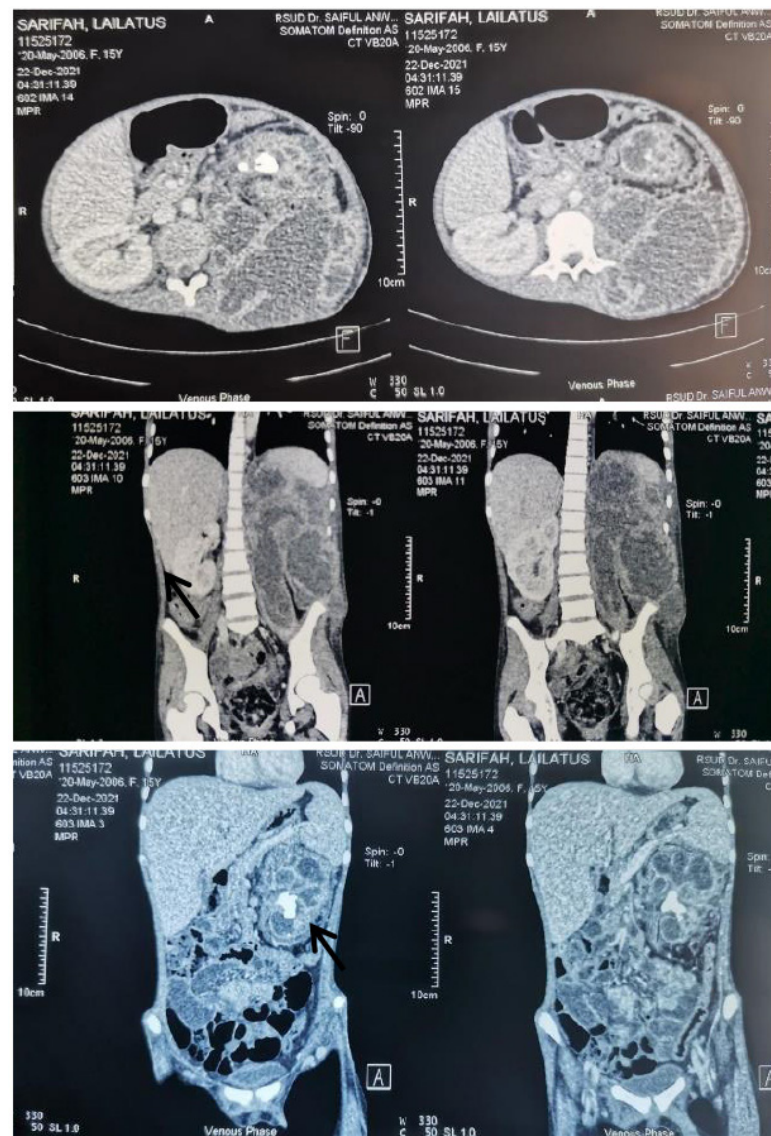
Abdominal CT showed a staghorn calculus in the left renal pelvis with an associated retroperitoneal abscess extending into surrounding tissue. Mild hydronephrosis on left renal due to nephrolithiasis and multiple paraortic lymphadenopathy.
